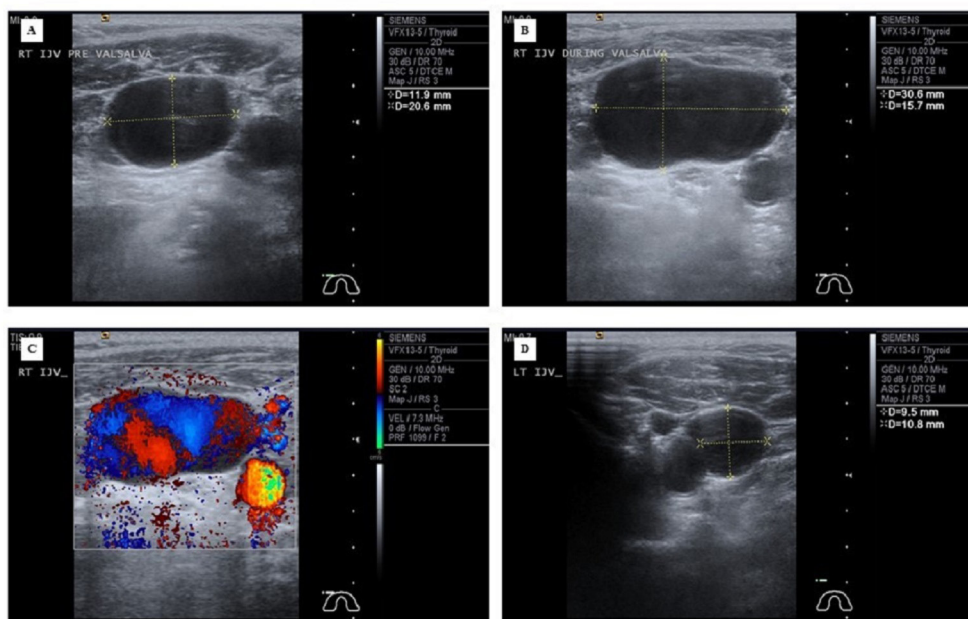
Ultrasonography shows the right IJV at rest (A) and during the Valsalva manoeuvre (B). Color Doppler demonstrated turbulent flow within the right IJV (C). The left IJV at the same level at rest was normal in diameter (D) with no significant changes in size during Valsalva manoeuvre.
